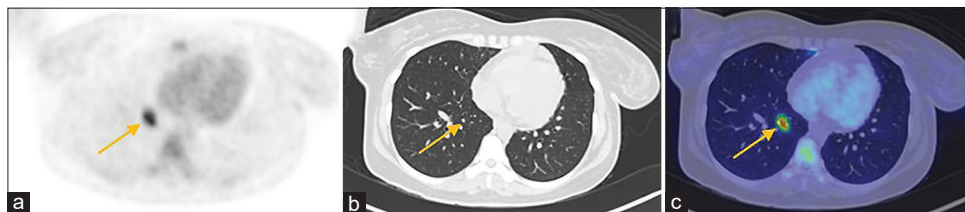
MIP PET image (a), CT scan lung window (b) and axial fused image (c) from FDG PET/CT of a 31-year-old lady who had mediastinal and cervical lymphadenopathy, showed an intense focus of metabolic activity in the right lower lobe without any abnormality in the lung window (yellow arrow), consistent with a hot clot.
